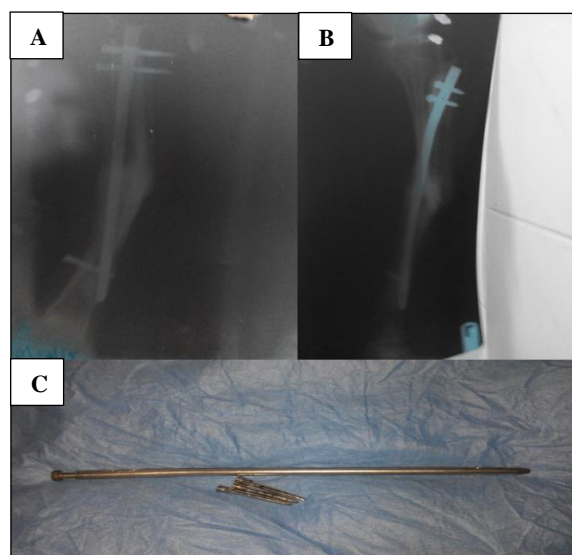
Plain radiographic views of united tibial fracture (1A and 1B) with intramedullary nail in situ. Removed SIGN nail with bolt in situ (1C).
